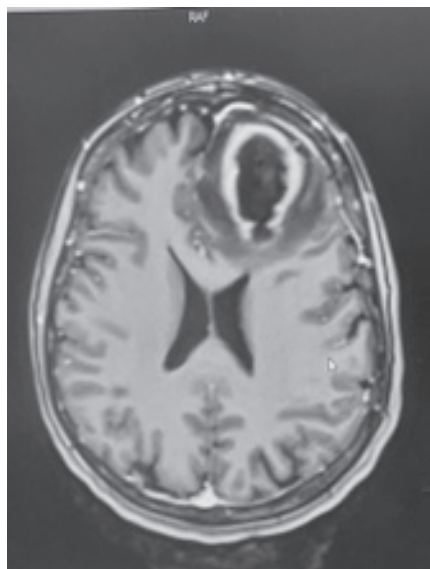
Shows a T1 MRI with a contrast-enhancing lesion.
